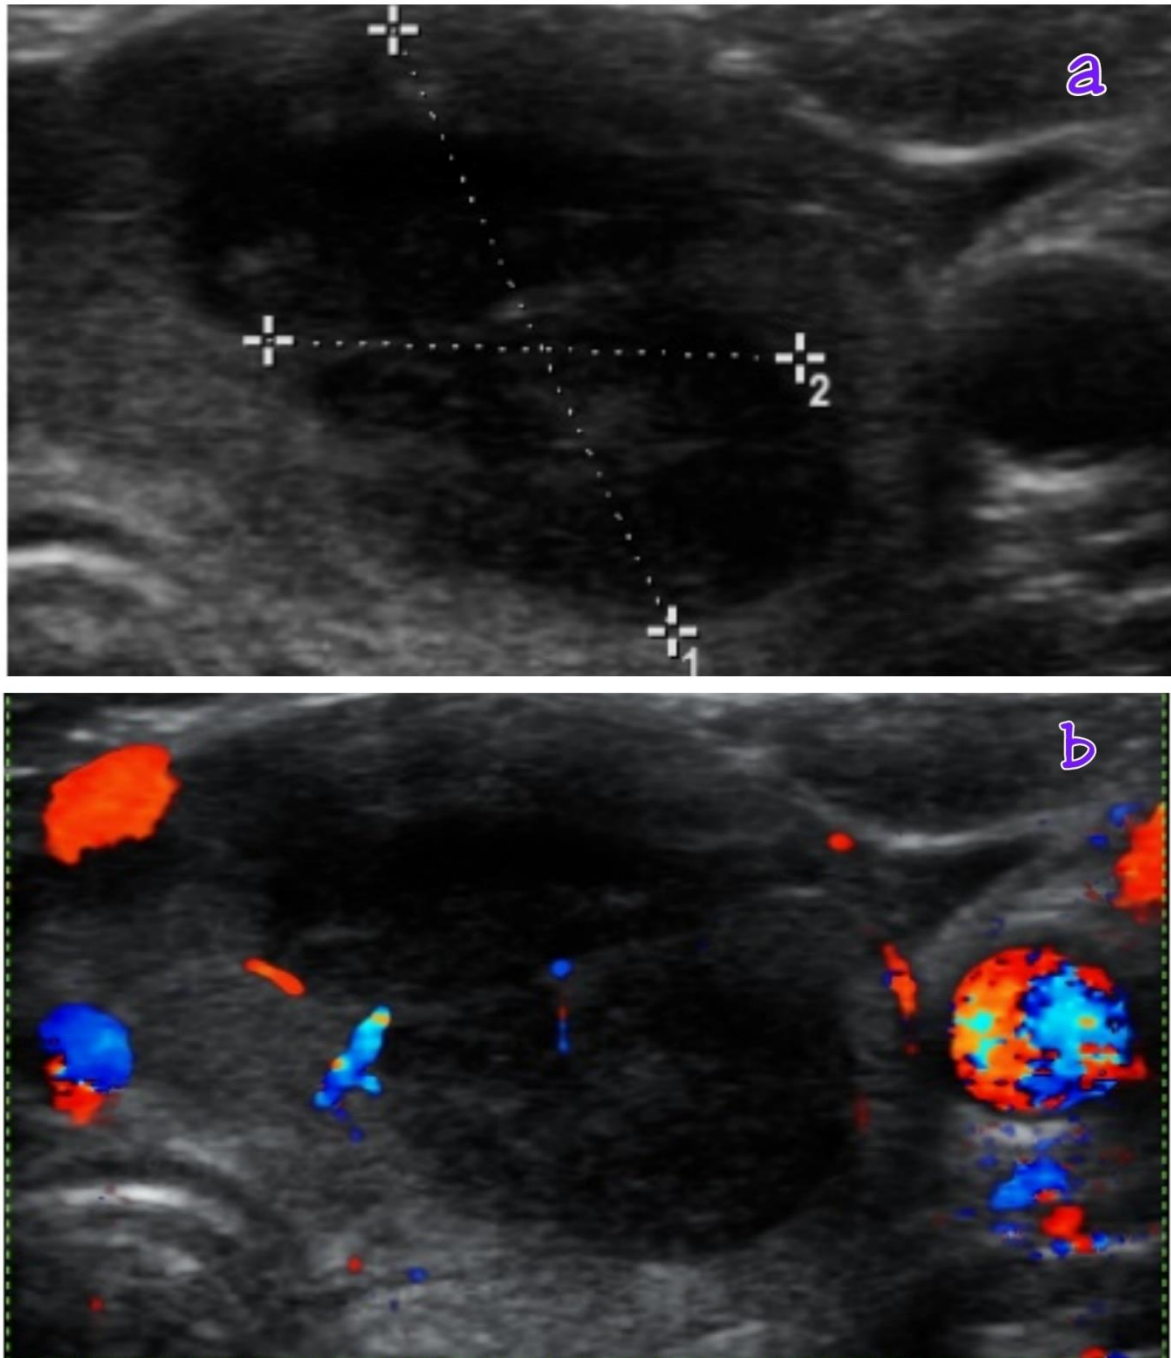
1. Ultrasonography Thyroid
